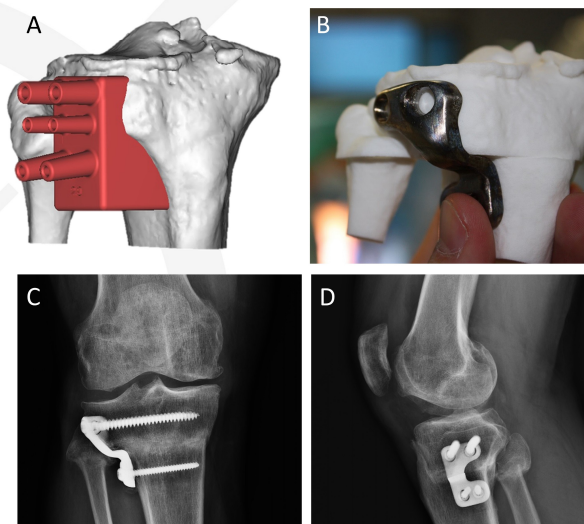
Design of the personalized guide (A), 3D printing of the plate (B) and X-ray of the surgical intervention (C, D).
